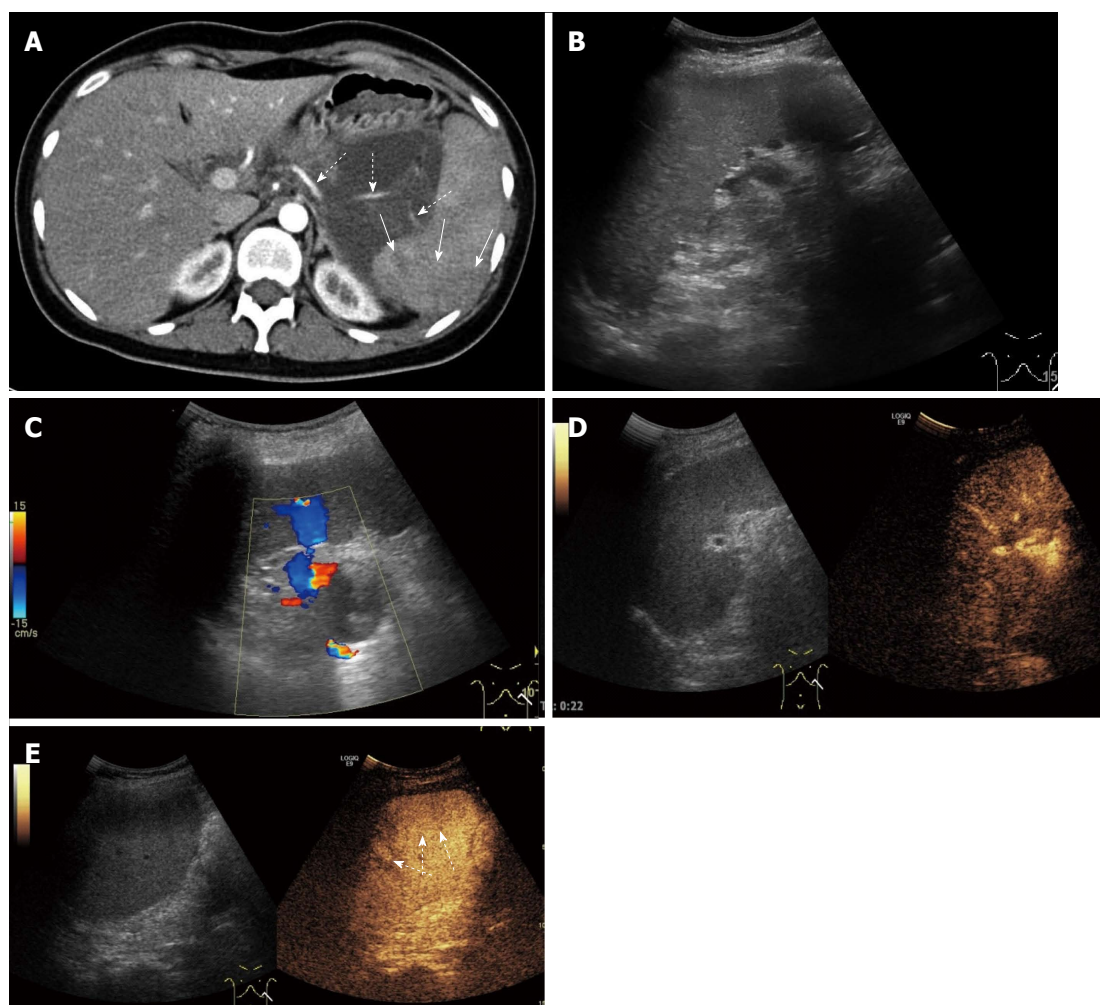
A 26-year-old woman with splenic arterial stenosis. A: Enhanced-contrast computed tomography showing splenic arterial stenosis (dotted arrow) and a focal splenic parenchyma region showed low enhancement (solid arrow); B, C: Gray scale ultrasonography and color Doppler ultrasonography showed no obvious lesions in the spleen; D: No obvious lesion was displayed in the splenic arterial phase on contrast enhanced ultrasound (CEUS); E: Some regions of focal dysperfusion of the splenic parenchyma showed low enhancement in the splenic venous phase (dotted arrow).
